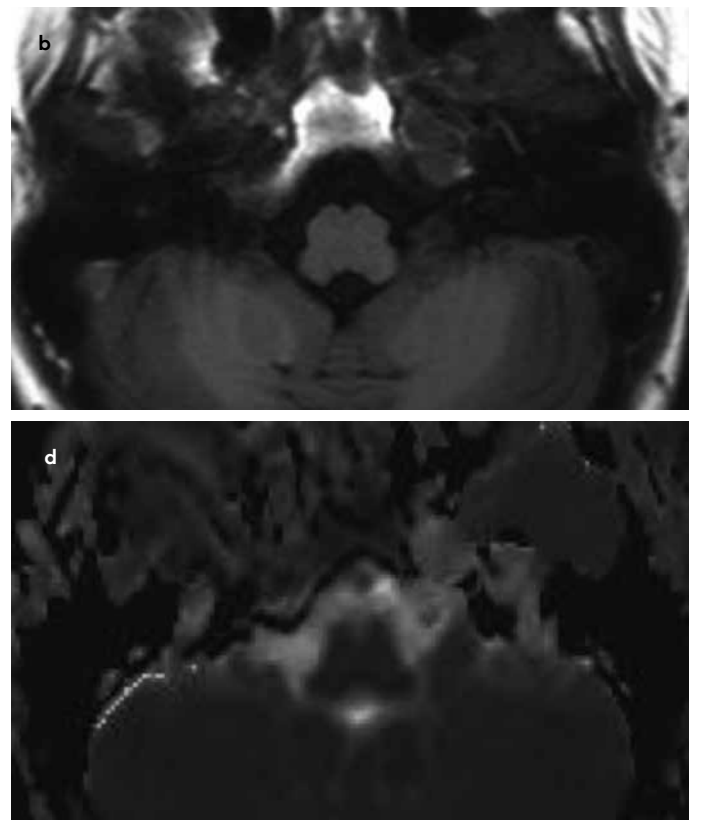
a-d. Petrous apex mucocele. Left petrous apex demonstrates mild expansion and high T2 (a) and low to intermediate signal intensity on T1-weighted image (b). The b1000 DW image (c) and corresponding ADC map (d) show that diffusion is not restricted.
